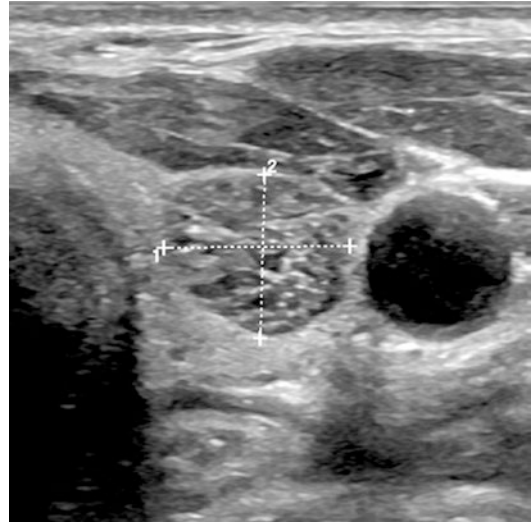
This spongiform nodule is safely benign and needs no FNAC for further work-up, even when cold on scintigram—the latter finding being explained by an abundant content of fluid
